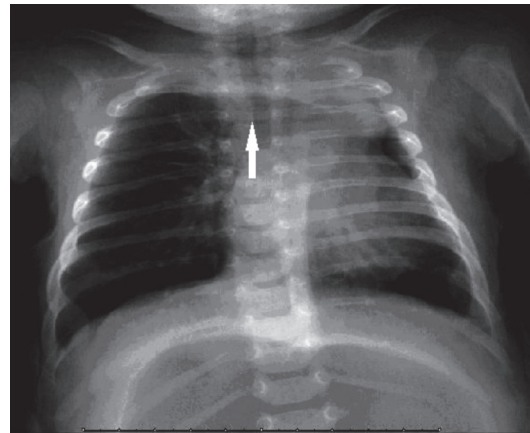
Postoperative chest x-ray demonstrated healing of right mediastinal shift and midline located trachea.
